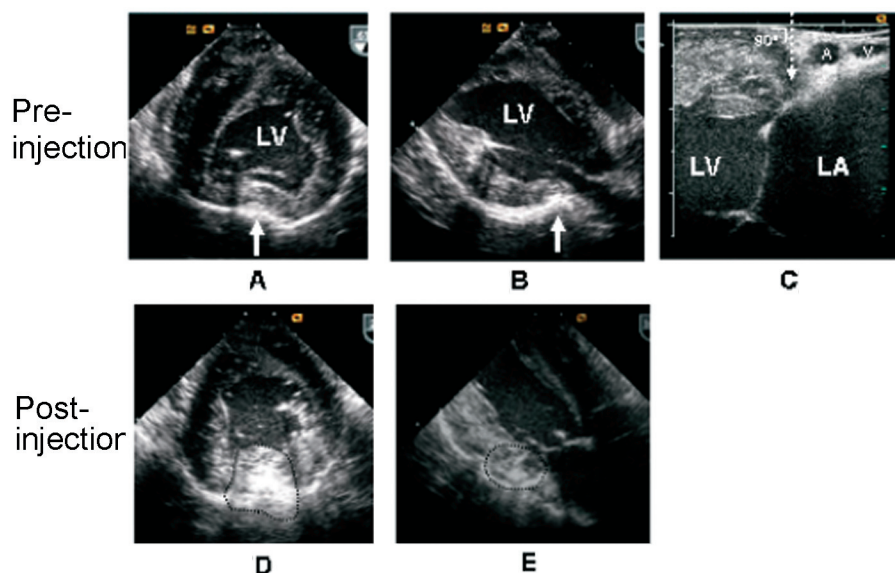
Two-dimensional epicardial echocardiographic images taken during the injection procedure. A and B, The puncture site at the atrioventricular groove was determined by compressing the epicardial surface in the short-axis (solid arrow in A) and long-axis (solid arrow in B) views. C, The depth of the injection site was determined in the view obtained by the linear epicardial probe. The dotted arrow indicates the puncture route that should be at a 90° angle with respect to the epicardial surface. D and E, The hydrogel mass was located in the middle of the posterior mitral annulus in the short-axis view (D). The geometry of the mitral annulus was manipulated in the short-axis (D) and long-axis (E) views. The dotted circles in D and E indicate the hydrogel mass. LV indicates left ventricle; LA, left atrium; A, left circumflex artery; V, coronary sinus.
